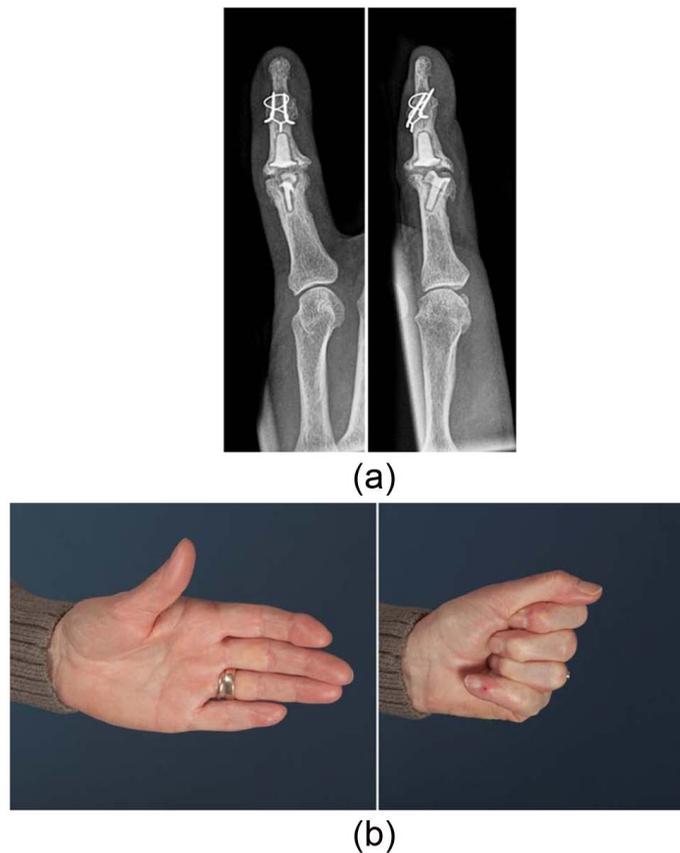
A 64-year-old patient. Postoperative x-rays show a migration and rotation of the proximal implant 6.8 years after implantation of a pyrocarbon prosthesis for the PIP joint of the little finger (a). However, the clinical examination demonstrates a range of motion of 60° (b).
